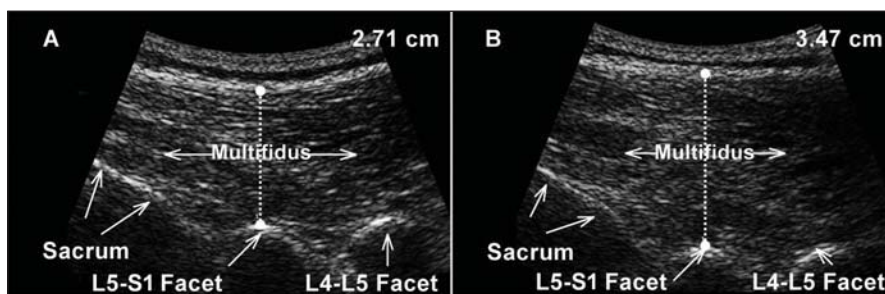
Sonogram of a parasagittal view of lumbar spine with the L5-S1 facet joint in the center. Measurement demonstrating a 28% thickness change of the lumbar multifidus between rest (2.71 cm, left panel) and automatic recruitment (3.47 cm, right panel) via contralateral arm lifting with load.
